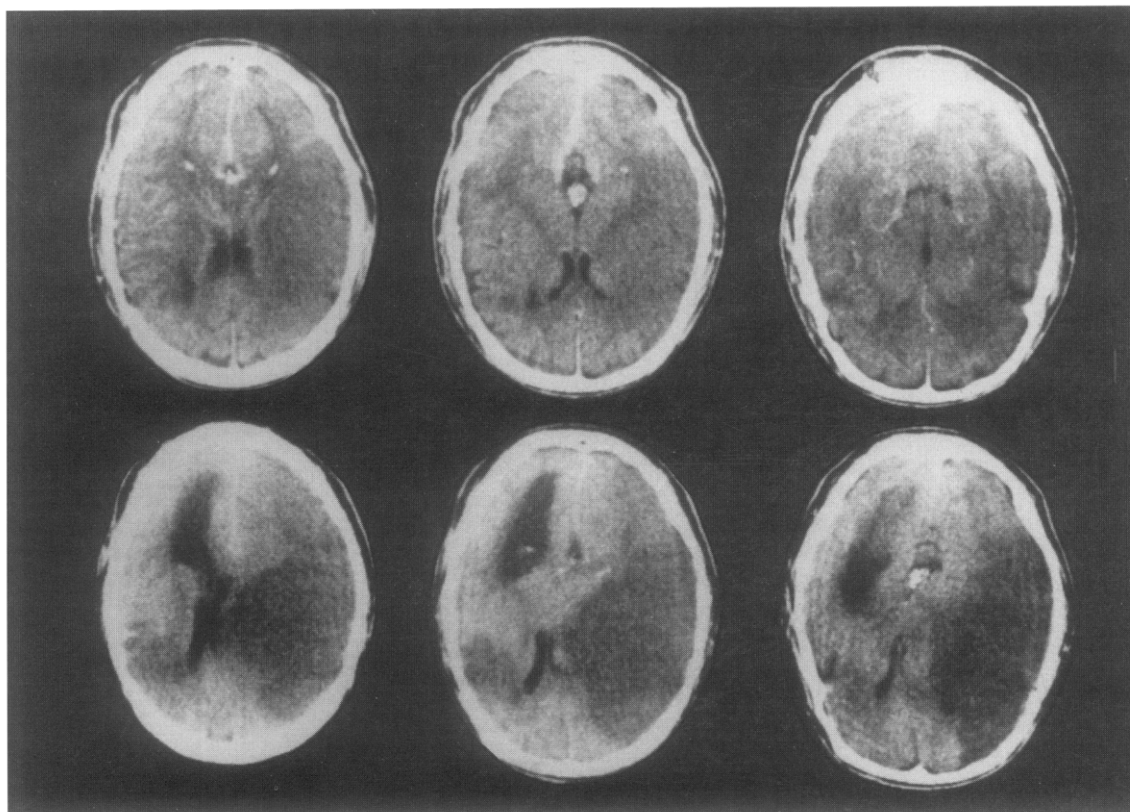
Computed tomographic scans of a patient with right middle cerebral artery infarction resulting from infective endocarditis. This patient underwent a Bentall-type operation for graft infection on the same day, resulting in massive brain swelling, and died 3 days later. *Top row*, Preoperative computed tomographic scans; *bottom row*, postoperative scans.
